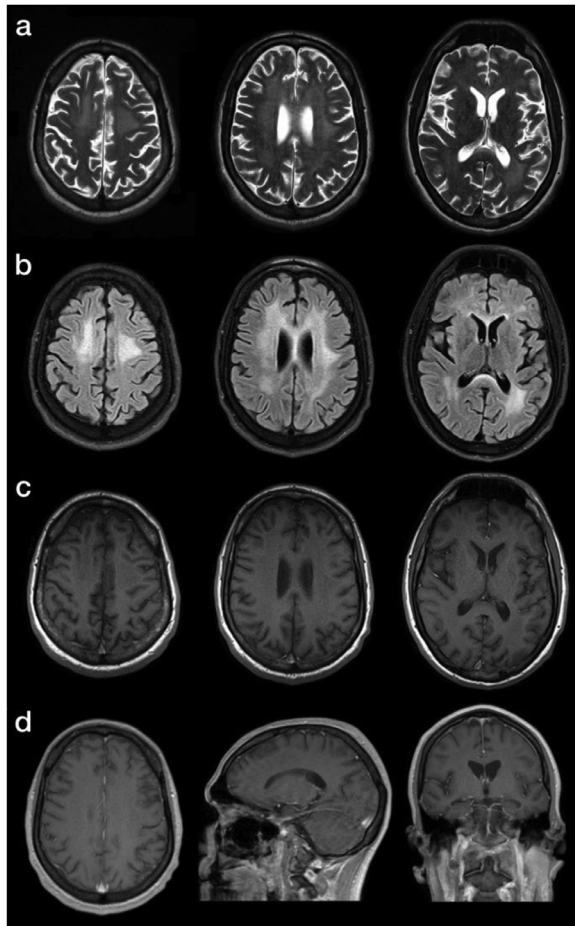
Axial T2 (A), FLAIR (B), and T1 (C) magnetic resonance imaging (MRI) of the brain demonstrate confluent bilateral T2/FLAIR hyperintense signal and mildly T1 hypointense signal in the periventricular white matter and centrum semiovale with relative sparing of the subcortical white matter and subcortical U-fibers. Post-contrast T1 images (D) did not show any associated enhancement. Additionally, generalized atrophy that is advanced for his age was noted.
